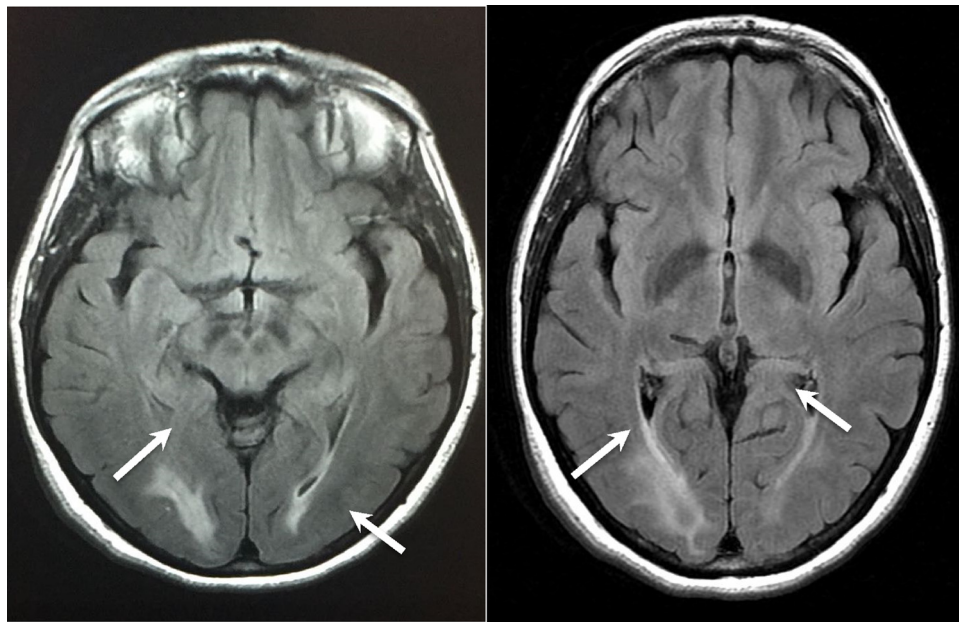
Brain MRI. Arrows indicate Bilateral symmetrical occipital cortico-subcortical high T2/FLAIR signal intensity suggesting a vasogenic oedema within the occipital and parietal regions most likely relating to the posterior cerebral artery supply This confirm Posterior Reversible Encephalopathy Syndrome (PRES).
